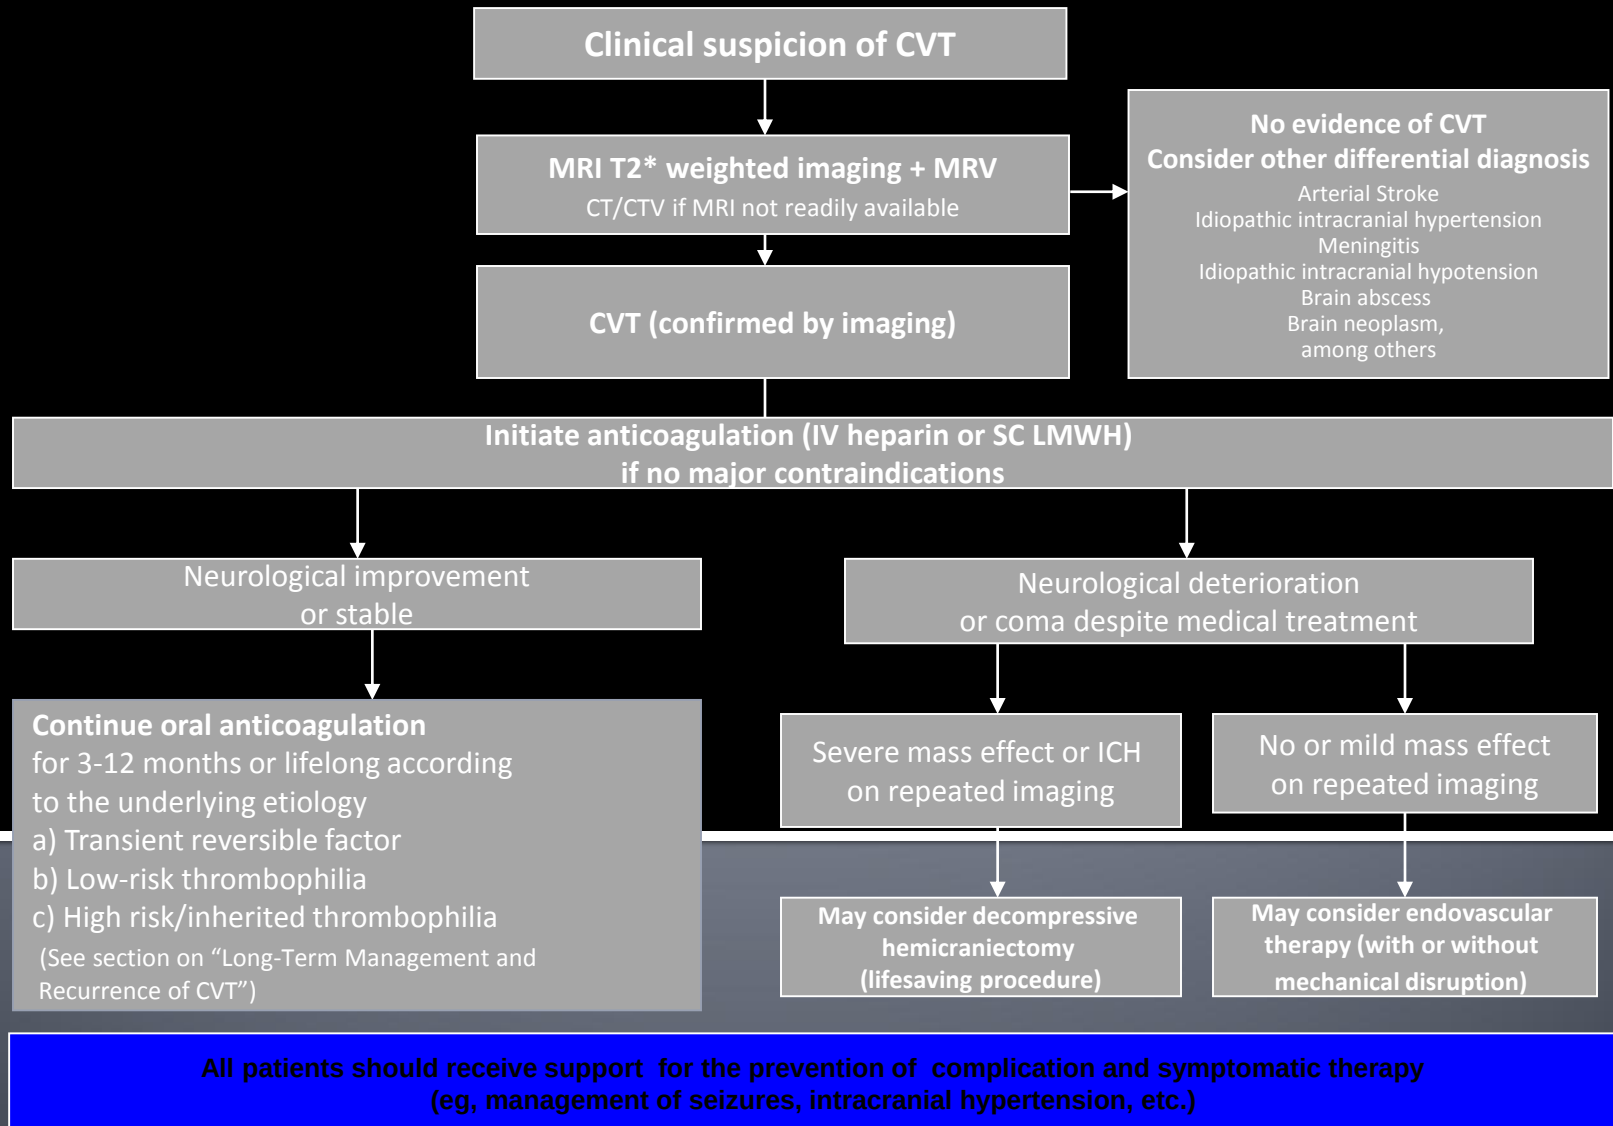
Cerebral venous thrombosis (CVT). CTV indicates CT venography; ICH, intracranial hemorrhage; IV, intravenous; MRV, magnetic resonance venography; and SC, subcutaneous.
